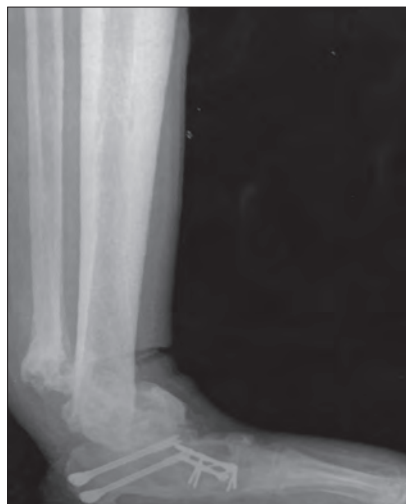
Lateral pre-op X-ray
